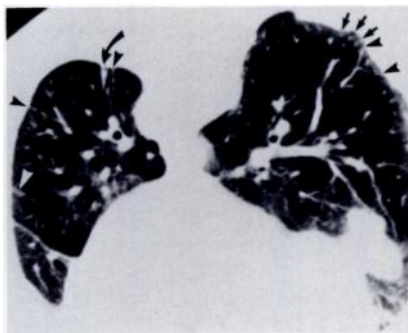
High-resolution CT scan with subject prone shows discrete parenchymal band in left base that contacts pleural surface (*curved arrow*). Thickened interstitial structures are evident in subpleural parenchyma bilaterally, including dotlike structures (*straight arrows*) and thickened short lines (*arrowheads*).
